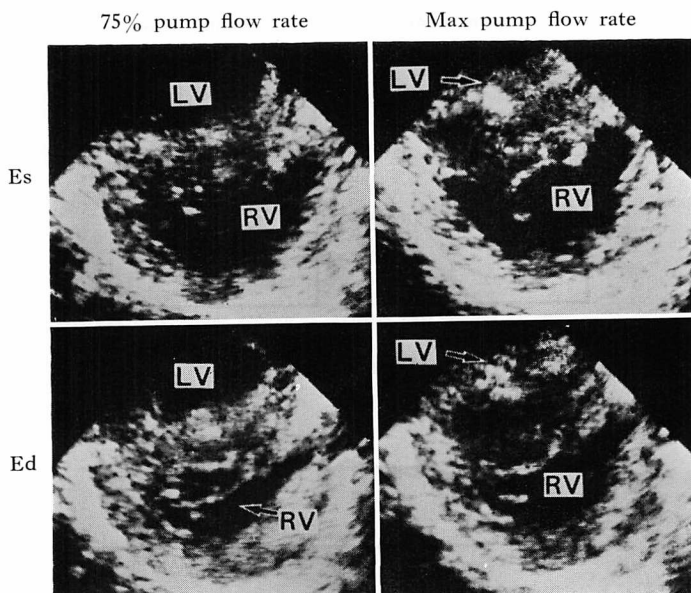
Two-dimensional echocardiograms during left heart bypass at the 75% and the maximum bypass flow rate.
